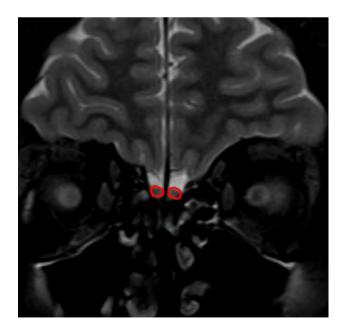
Olfactory bulb volume measurement with magnetic resonance imaging. Coronal T2-weighted image shows an example measuring of olfactory bulb surface area
